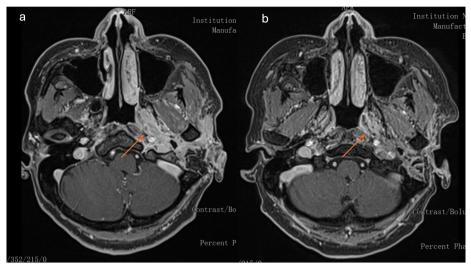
(a) Axial contrast-enhanced T1 magnetic resonance imaging (MRI) (third month of follow-up) showing a large area of post-gadolinium enhancement along the skull base, with infiltration of the parotid gland, the temporomandibular joint, reaching the left parapharyngeal space till the nasopharynx, with involvement of the internal carotid artery and the internal jugular vein (orange arrow). (b) Axial contrast-enhanced T1 MRI image (1-year follow-up) showing the parapharyngeal space less contrasted, in contact with the external and internal carotid artery in its extracranial part, involving the carotid space (orange arrow).
